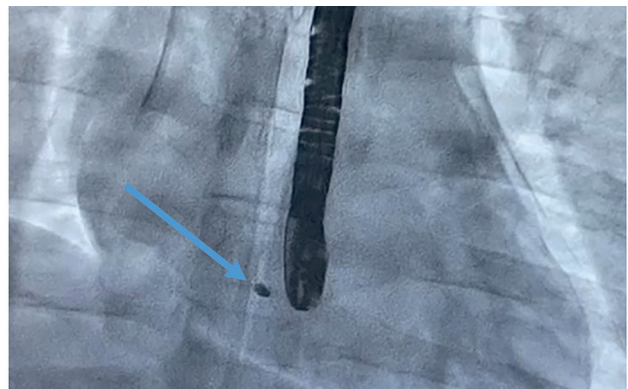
An X-ray examination revealed a foreign body (indicated by a blue arrow).
